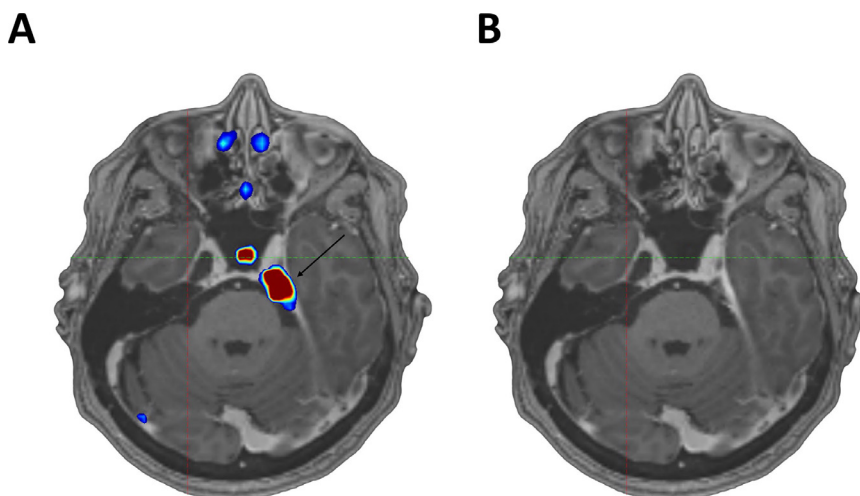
Positron emission tomography revealed left-sided skull base disease (black arrow, A) that was poorly visualized with magnetic resonance imaging alone (B).
